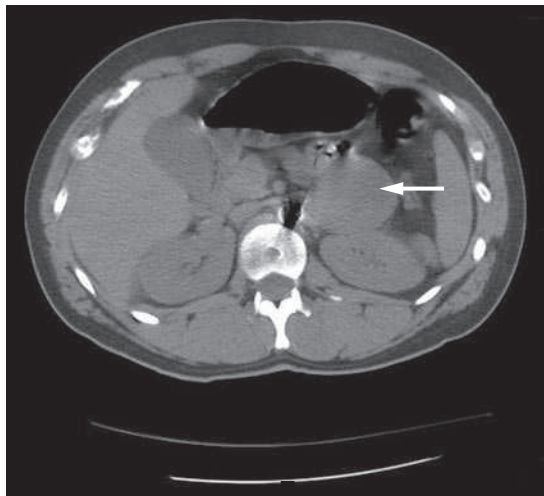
CT scan after the patient had been transferred to a surgical center. The image shows an 80 mm round lesion (arrow) adjacent to the upper pole of the left kidney.
